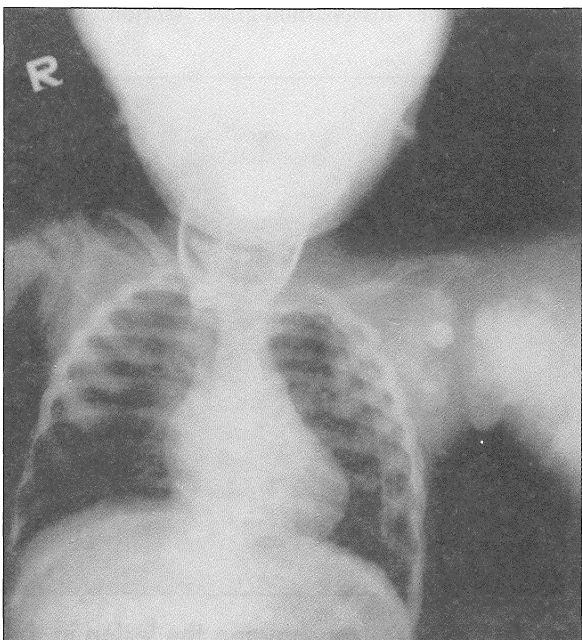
Plain X-ray showing secondaries to the lungs and right humerus.
